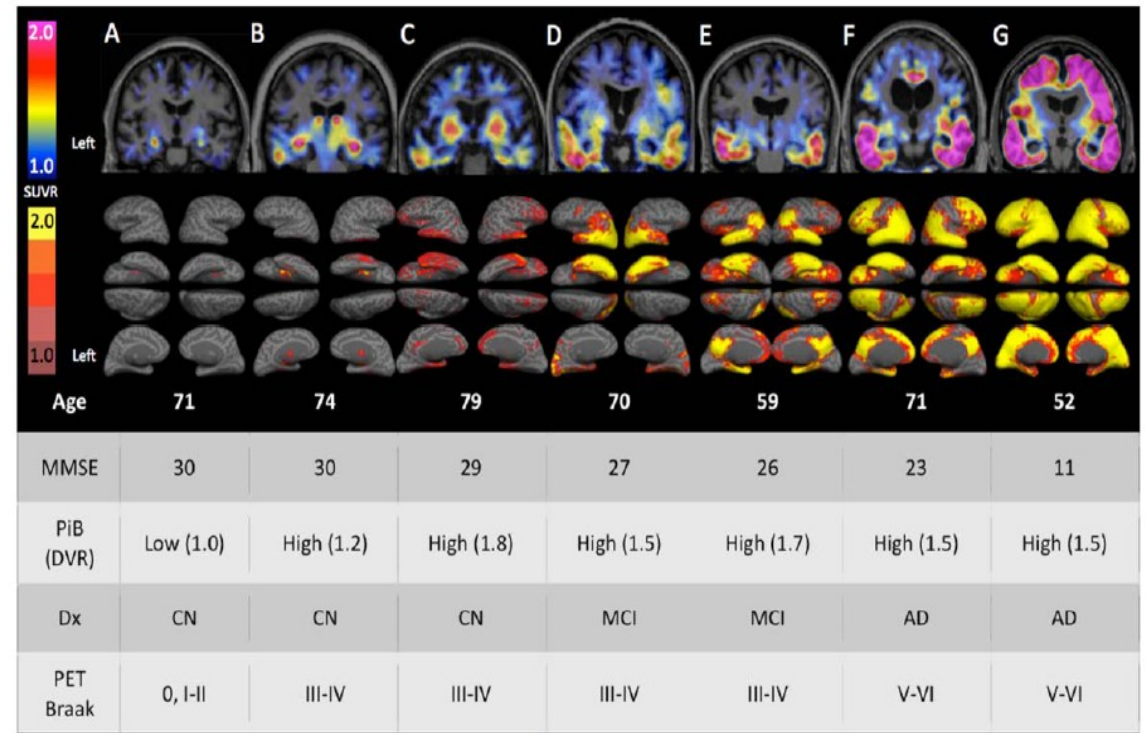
Cortical patterns of ¹⁸F T807 binding. Coronal ¹⁸F T807 positron emission tomographic (PET) images (top row) and whole-brain surface renderings of standardized uptake value ratio (SUVR; cerebellar reference; second row) from 3 clinically normal (CN) and 4 impaired (2 mild cognitive impairment [MCI] and 2 mild Alzheimer dementia [AD] dementia) participants. Top: (A) A 71-year-old CN subject with low amyloid β (A β) by Pittsburgh compound B (PiB) PET (mean cortical distribution volume ratio [DVR] = 1.0) had low, nonspecific ¹⁸F T807 binding in cortex, consistent with a Braak stage less than III/IV. (B) A 74-year-old CN subject with high A β (DVR = 1.2) with ¹⁸F T807 binding in inferior temporal cortex, left > right, consistent with Braak stage III/IV. (C) A 79-year-old CN subject with high A β (DVR = 1.8) had binding in inferior temporal neocortex, consistent with Braak stage of III/IV. B and C show focally intense subcortical uptake that is likely due to off-target binding (see Discussion). (D–G) Cognitively impaired participants all with high A β and with successively greater levels of cortical ¹⁸F T807 binding successively involving temporal, parietal, frontal, and occipital cortices. Bottom: ¹⁸F T807 SUVR calculated at vertices (see Subjects and Methods) indicating the extent of cortical binding, with left hemisphere views (lateral, inferior, superior, medial) at left. The 52-year-old AD dementia patient (G) showed confluent ¹⁸F T807 binding that is nearly pancortical, sparing only portions of primary cortex and consistent with Braak stage V/VI. Dx = classification; MMSE = Mini-Mental State Examination; PET Braak = estimate of Braak stages based on the anatomic pattern of T807 binding assessed visually and quantitatively in regions and full volume data.
